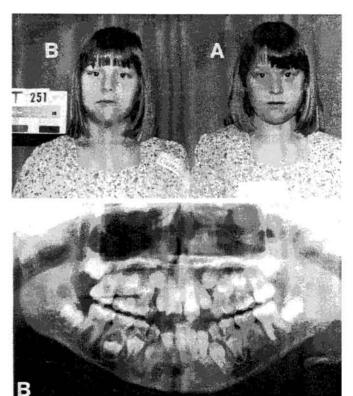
Monozygous twin girls (B and A), aged 10 years, 9 months. Panoramic radiograph B (twin B) lacks a left mandibular second premolar (empty socket under left dm2, seen on the right in the photograph). Panoramic radiograph A (twin A) lacks a right mandibular second premolar (empty socket under right dm2, seen on the left in the photograph).
